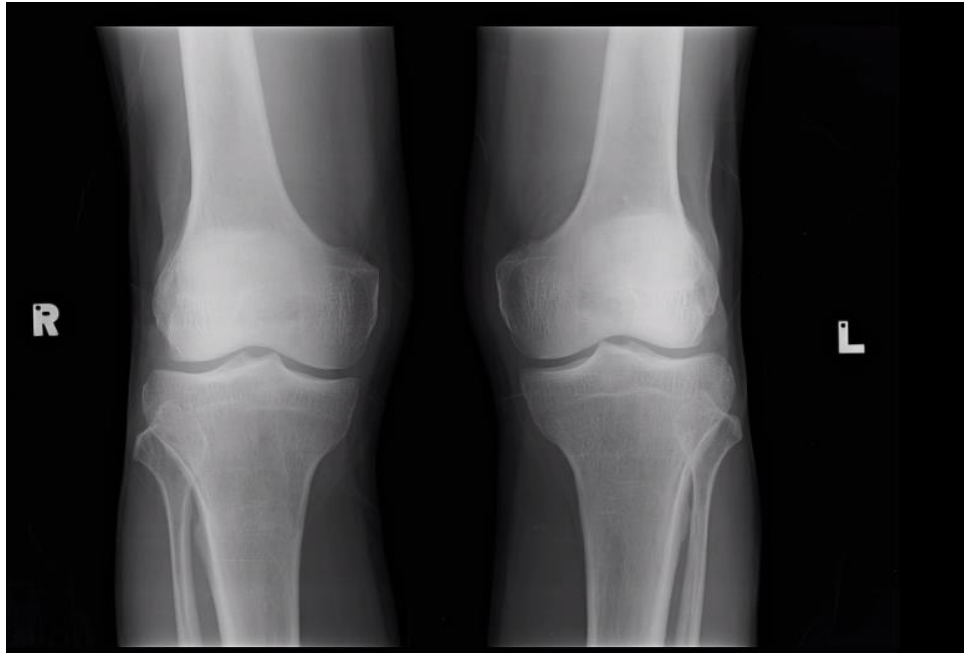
X-ray image for Normal knee
